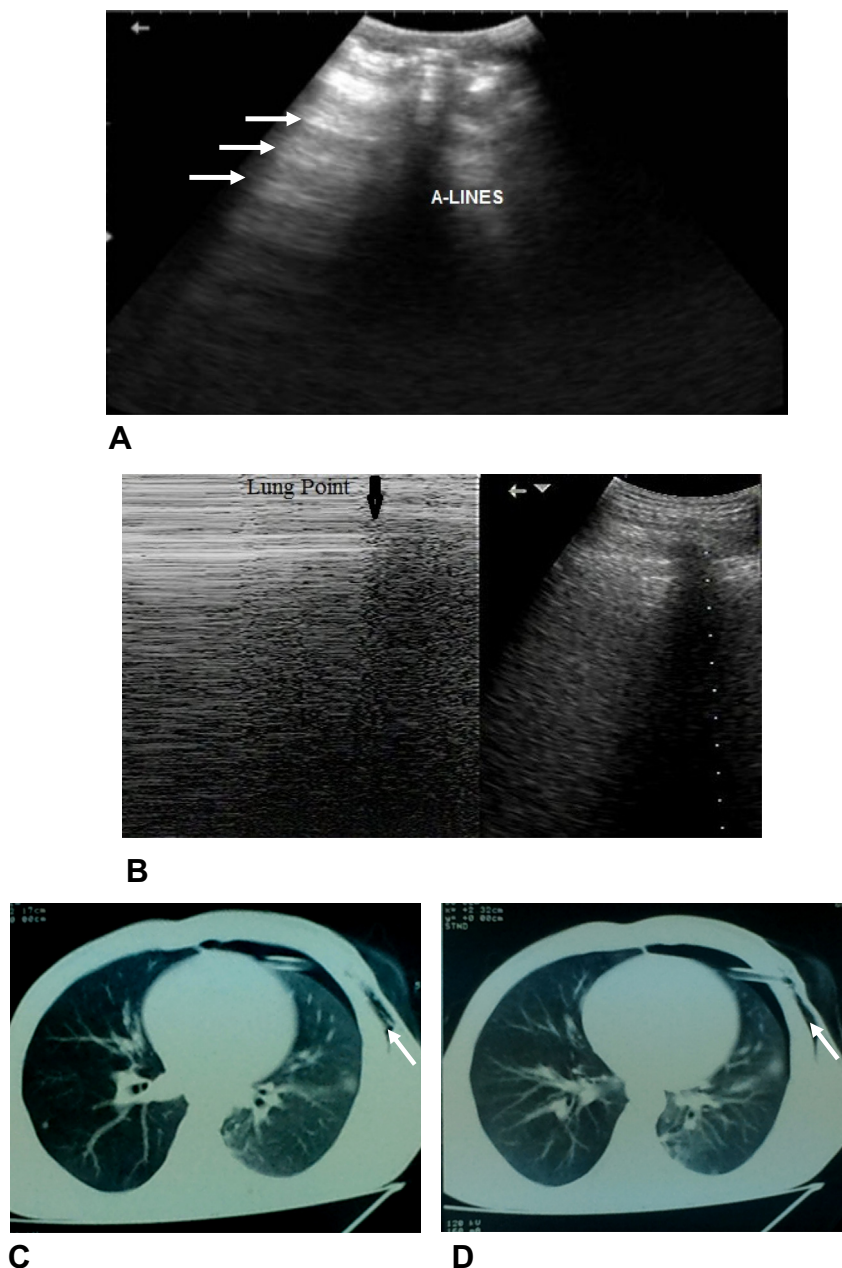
(A) Chest US image in B-mode displays a multitude of exaggerated horizontal reverberation artifacts (A-lines) (arrowed) seen in the form of echogenic lines parallel to the pleural surface and equidistant from each other. (B) Chest US image in M-mode reveals the lung point sign (arrowed) which is the transition point between strictly horizontal lines (the so-called “stratosphere sign”) and the normal granular pattern (the so-called “seashore sign”). (C and D) Postcontrast chest CT images in lung window settings display mild left-sided pneumothorax with partial compression collapse of the underlying lung and an intercostal tube seen in situ with surgical emphysema along the left lateral chest wall (arrowed).
